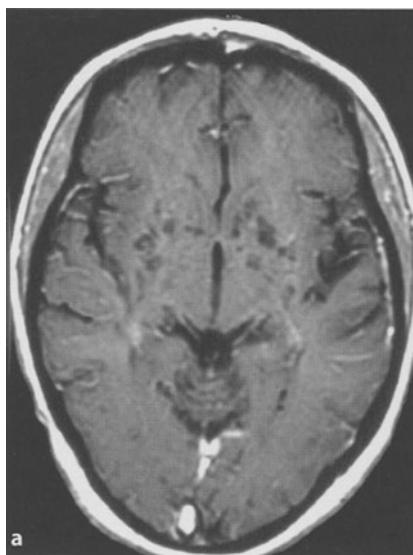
Nineteen-year-old girl affected by HIV infection and cryptococcal meningoencephalitis, with severe papilledema and high CSF pressure at lumbar puncture (opening pressure 40 mmHg) without hydrocephalus. MRI shows dilated perivascular Virchow-Robin spaces (a) and large parietal cryptococoma (b)
